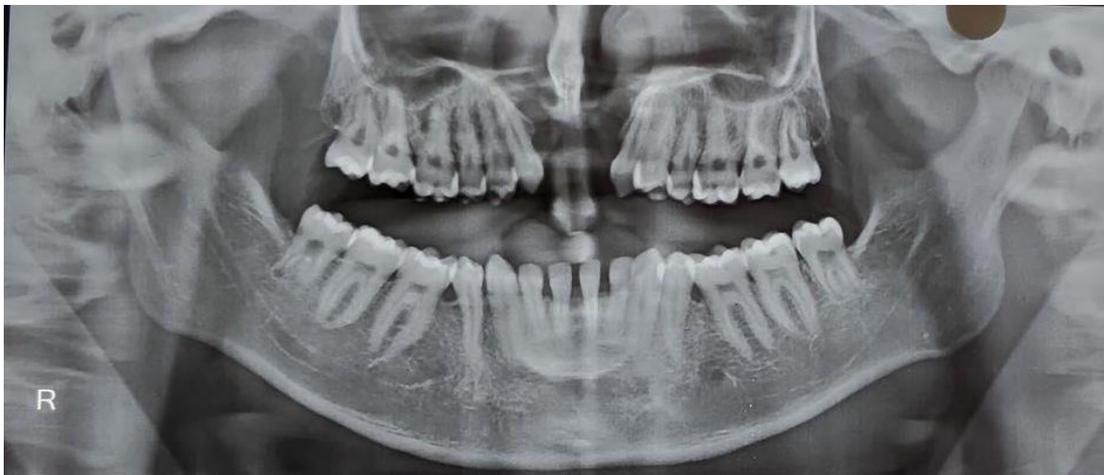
Orthopantomogram showing absent mandibular 1st premolar and maxillary lateral incisors.
